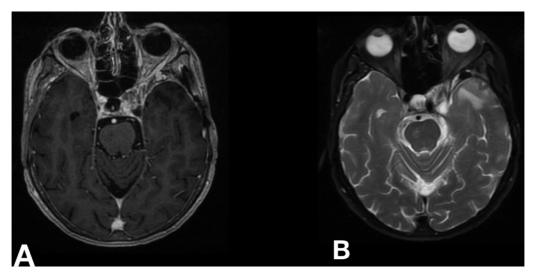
Postoperative MRI brain after 15 months. Axial T1 weighted with contrast (A) and axial T2 weighted images (B) show no recurrence.
